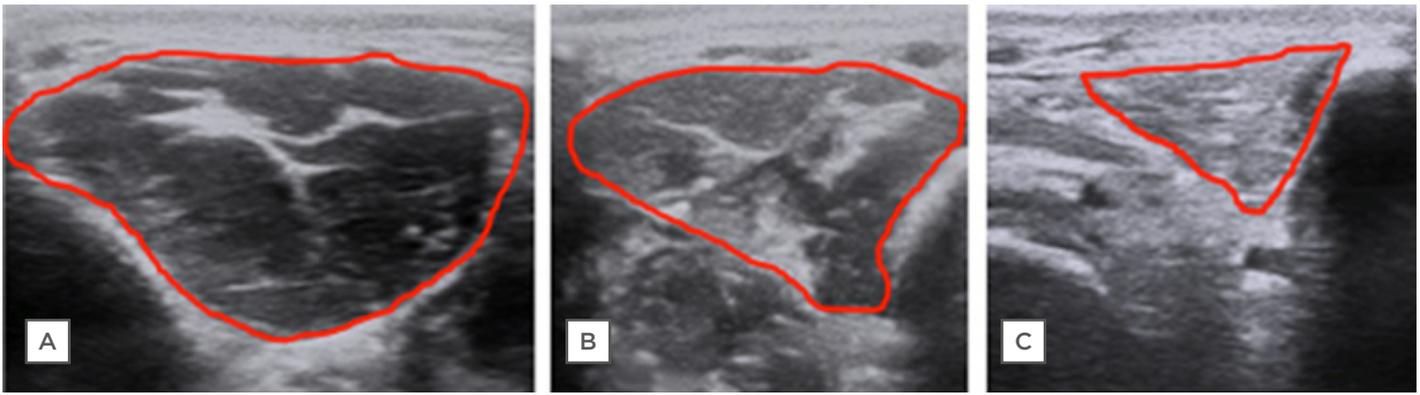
Ultrasound of the first dorsal interosseous muscle.
